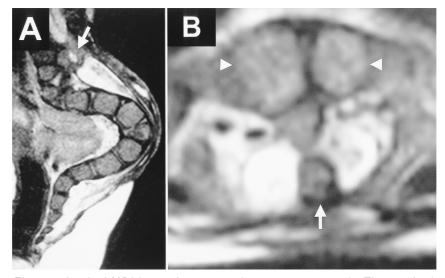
A spinal MRI image demonstrated an osseus spur on the Th8 vertebral column coexisting butterfly vertebrae at Th8. (A) Sagittal T2-wighted MR image shows a bony spur (arrow). (B) Horizontal T2-weighted MR imaging demonstrate butterfly vertebrae(arrowheads) and a bone spur (arrow).
